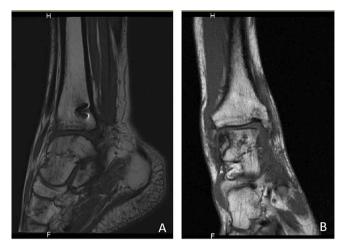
Magnetic resonance imaging of right ankle after removal of all screws in 14 months of the follow-up: complete union of talar neck fracture (A) sagittal view (B) coronal view.
